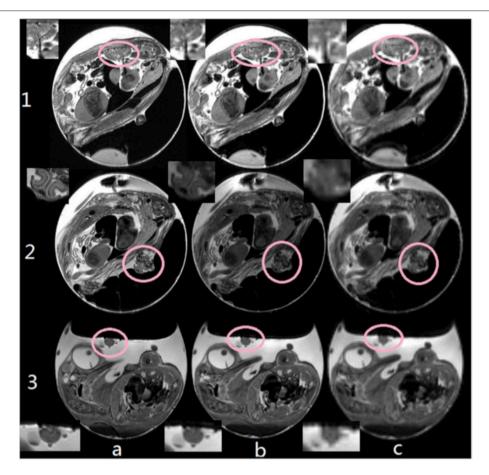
Comparison between different image resolution: (a) 77 × 91 μm², (b) 200 × 200 μm², and (c) 500 × 500. With increasing resolution, details of e.g., the pulmonary veins (1), the beak (2, axial orientation), and tumor tissues (3) could be clearly resolved. Insets show details of the respective target structures. This research was originally published in NMR Biomed: High-resolution MRI analysis of breast cancer xenograft on the chick chorioallantoic membrane. Zuo et al. [61].
